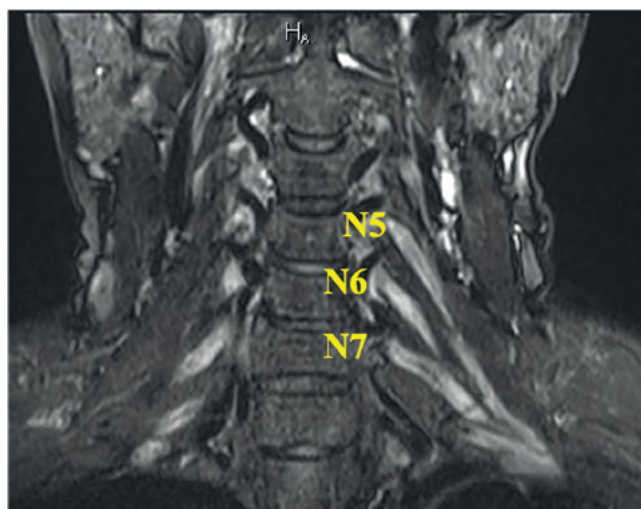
BP MRI in a MMN patient (10-year follow-up history, pre-therapy assessment).
